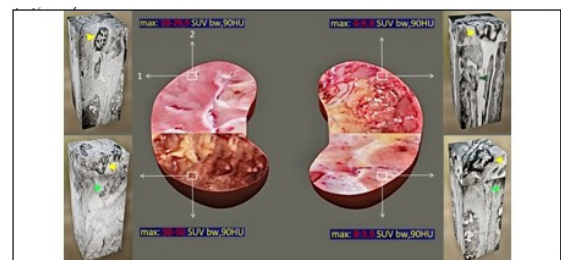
Clinical navigation scheme of the probable 3D ultrastructural state of the nephron at $10,000\times$ magnification and the 3D anatomical structure of the renal parenchyma based on the digital PET/CT standardized uptake value (SUV) of ¹⁸F-FDG.
